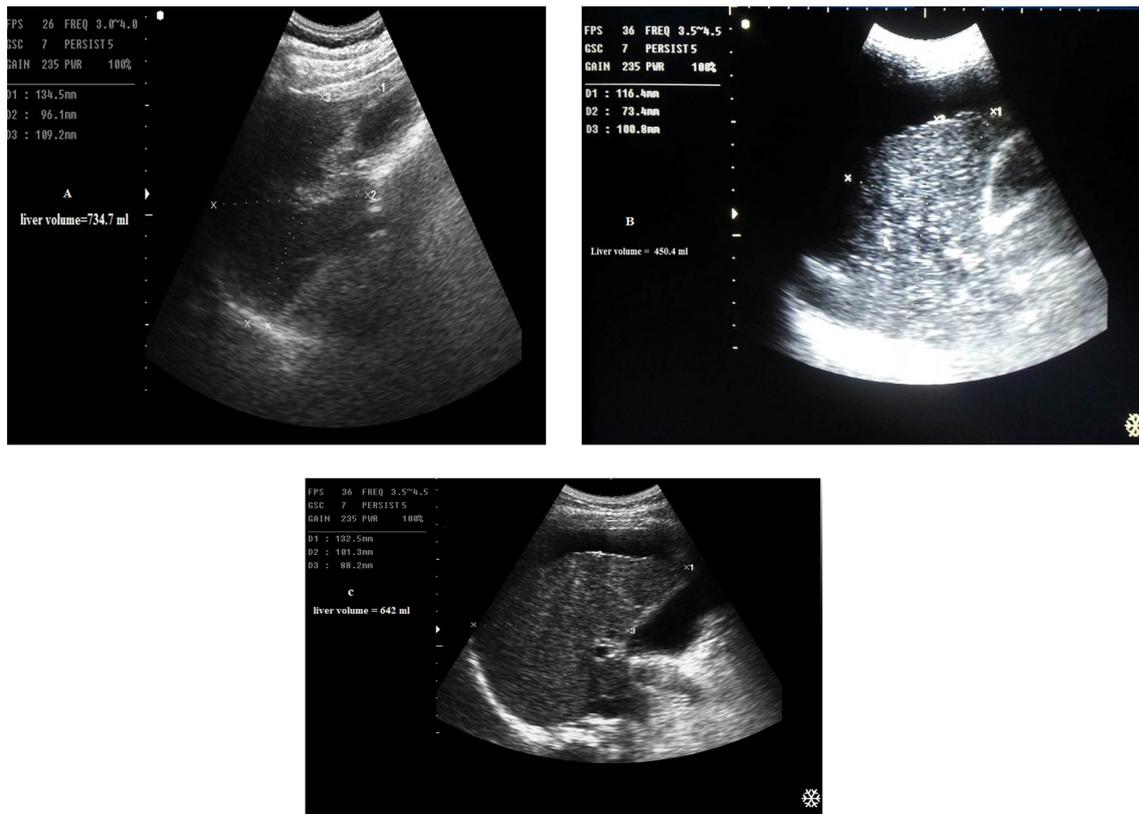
manual liver assessment by ultrasound (max. length × max. width × max. depth × 0.523) a Liver volume = 734.7 ml, b shrunken liver with a volume of 450.4 ml, c cirrhotic liver with ascites and a liver volume of 642 ml
